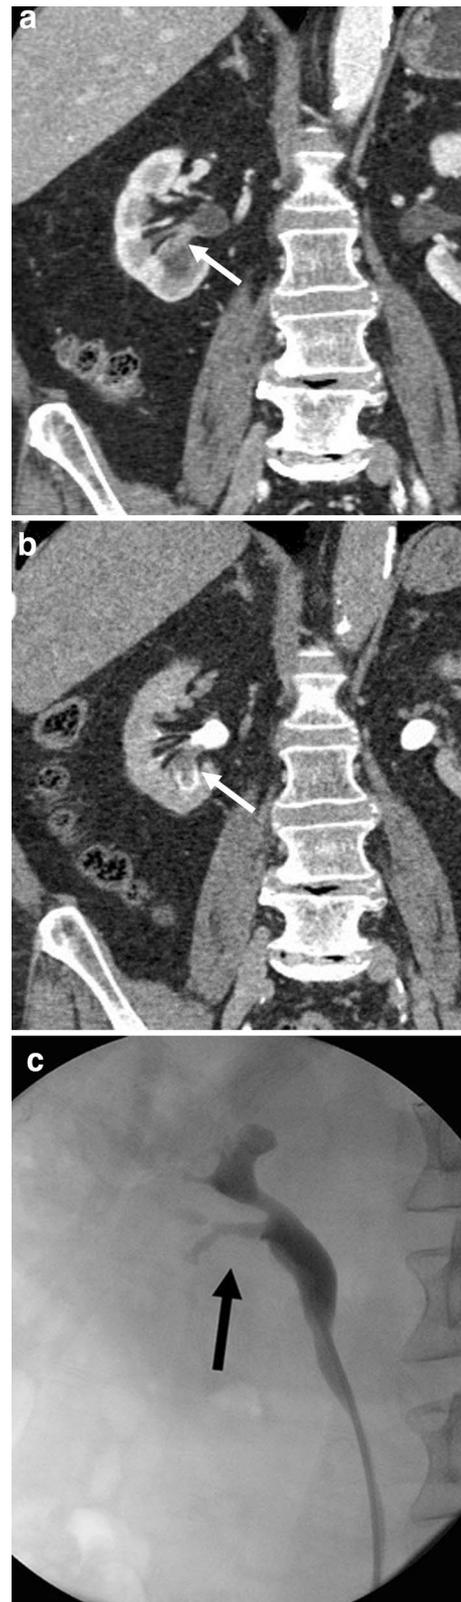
CT urogram obtained during the nephrographic (a) and delayed (b) phase demonstrates soft tissue with filling defect within the lower pole calyces of the right kidney (arrows). Retrograde pyelogram shows lack of filling of lower pole calices (black arrow) due to an obstructing mass (c). Urothelial carcinoma was found at pathology
